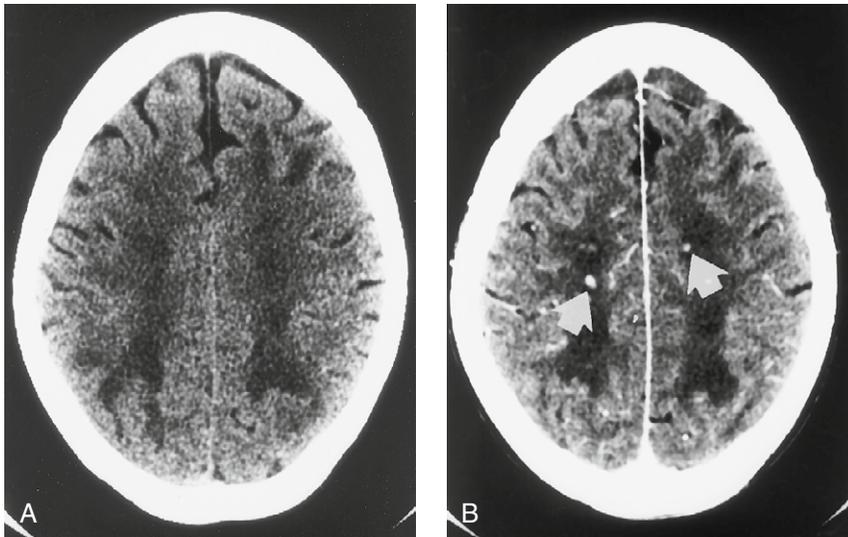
Candida* micro abscesses. (A) Non-enhanced CT scan shows abnormal low density within the white matter. (B) Contrast CT scan shows punctate enhancing candidal microabscesses (white arrows). (Case courtesy of Dr Richard Dahlen, San Antonio, TX.)
